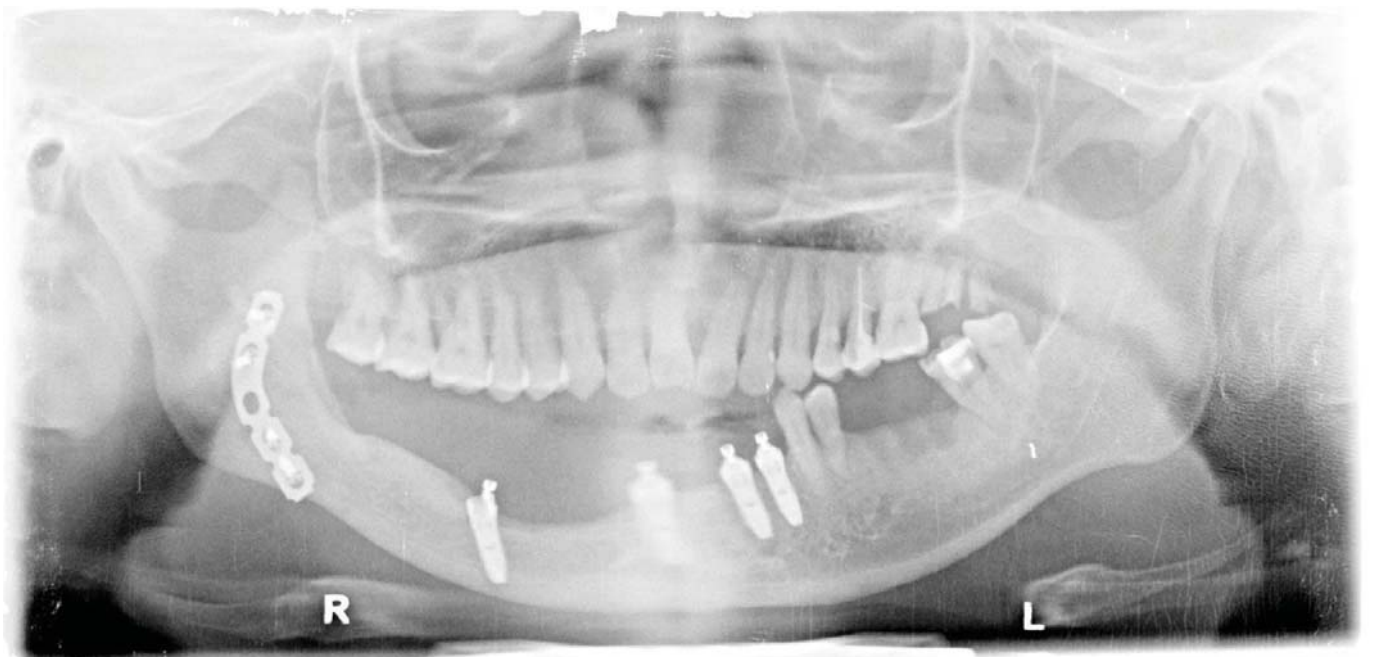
The panoramic radiograph of the implant placement. Noted that fixation plate was inserted in the right side of the mandible.
